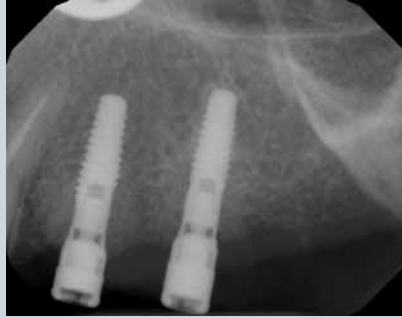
Post-operative radiograph after implantoplasty and guided bone regeneration.
